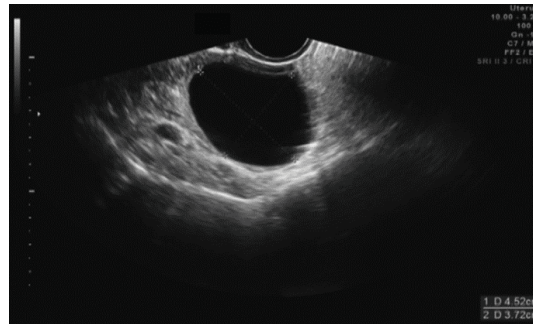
Transvaginal sonogram of an adnexal mass using IOTA-SRs diagnosis of benign tumors. Postoperative pathology proved that it was a luteal cyst
